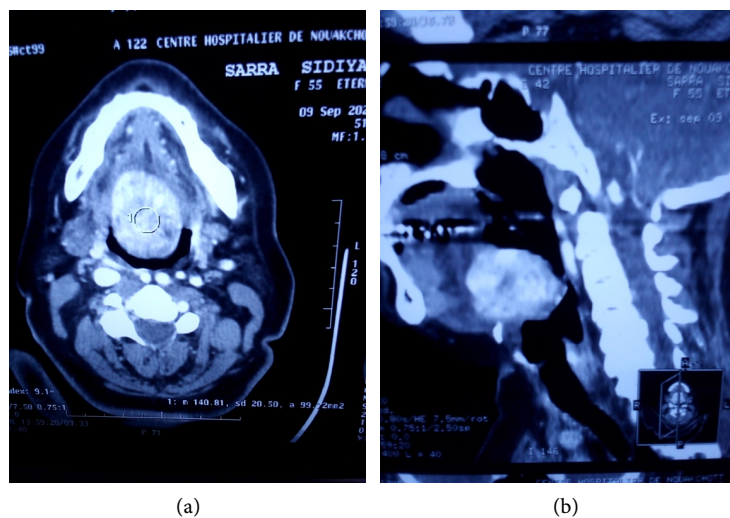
Cervical CT scan: Axial section (a) showing enhancement homogeneous tumor after injection of contrast product. Sagittal section (b): the well-defined mass, reducing the diameter of the oropharynx.
